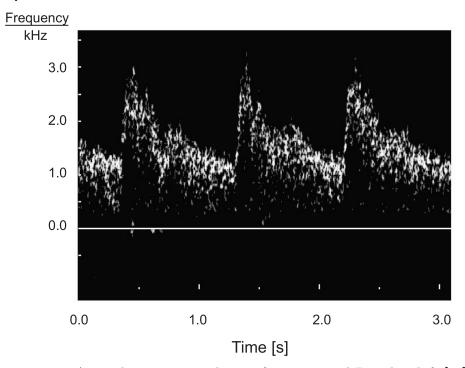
Arterial sonogram with time-frequency and Doppler shift [19]
